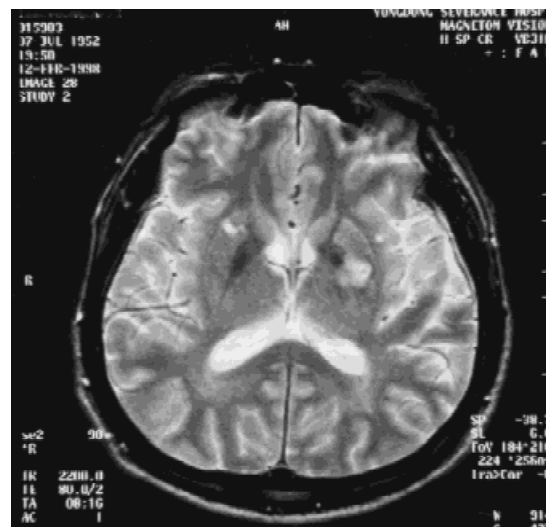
Axial T2-weighted brain MRI scan of case 3 shows high signal-intensity lesions involving the anterior part of the right putamen and the posterior part of the left lenticular nucleus.
